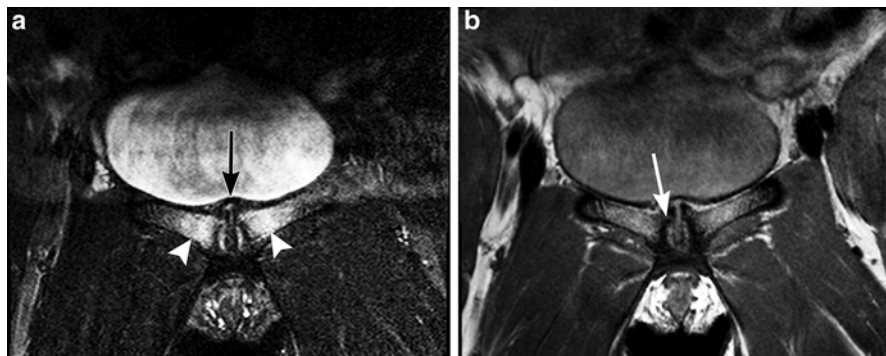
A 30-year-old woman, 6 months after first birth by cesarean section now presents with increasing pubic pain. MRI of the pubic symphysis with (a) coronal STIR demonstrates joint line sclerosis and osteophyte formation (*black arrow*) and bright bone marrow edema from stress injury (*white arrowhead*) consistent with osteitis pubis. Standard body sequence (b) coronal T1 demonstrates only the parasymphyseal sclerosis and osteophyte formation (*white arrow*). The patient had returned to active soccer playing and complained of increased pubic pain now greater than before pregnancy. Postpartum athletes with osteitis pubis before pregnancy can have severe onset of pain soon after returning to their sport [53]
